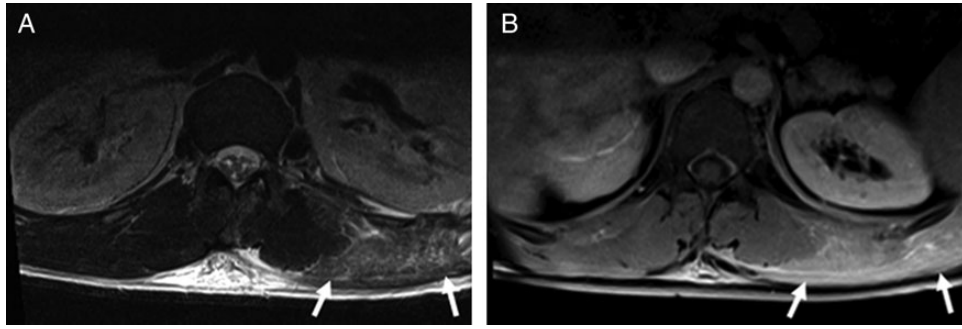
Axial T2 (A) and T1-weighted (B) images with fat saturation through the thoracolumbar region after intravenous gadolinium administration demonstrating high T2 signal and enhancement in the left paraspinal muscles (arrows), and there is prominent edema in the overlying soft tissues.
